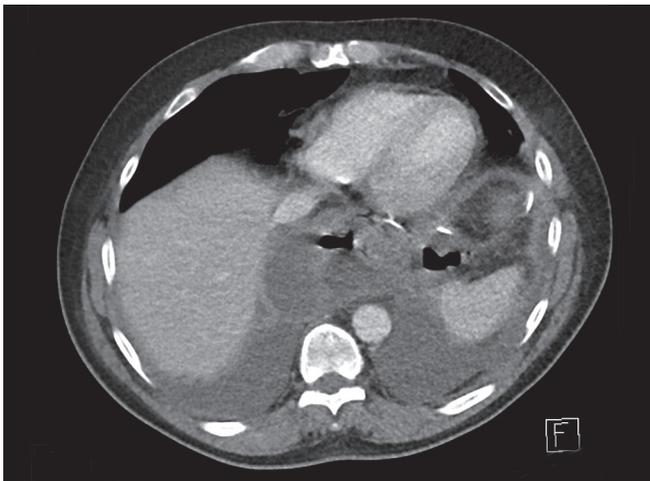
Axial contrast-enhanced CT showing a posterior mediastinal collection situated posterolateral to the esophagus
